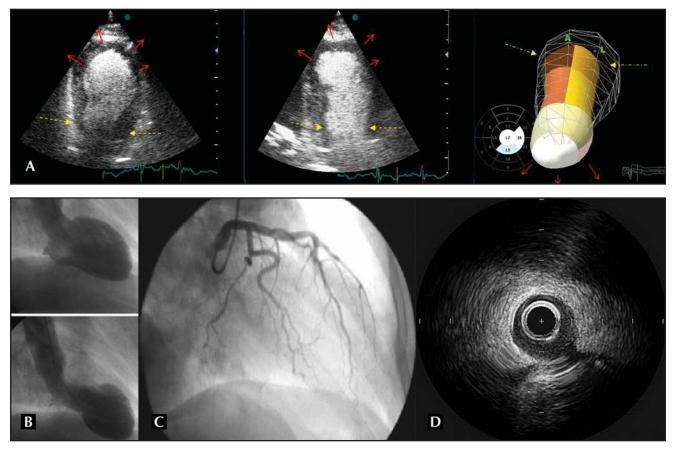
A, End-systolic frames of three-dimensional echocardiography and myocardial contrast echocardiography, showing apical ballooning and mild abnormal perfusion at the apex. *Red arrows* point out areas of abnormal wall motion. B, Angiography with left ventricular ventriculography showing apical ballooning. C, Normal left anterior descending artery (LAD) in the same patient at admission. D, Normal intravascular ultrasound from the proximal LAD.
